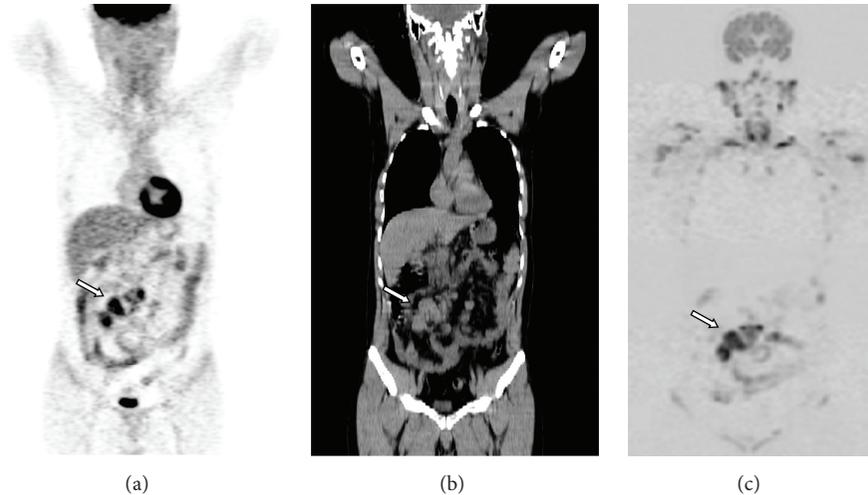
A 38-year-old man with intestinal DLBCL (diffuse large B-cell lymphoma): (a) MIP image of ^{18}F -FDG-PET, (b) coronal whole-body CT, and (c) MIP image of DWI. All techniques detected the primary intestinal lesion (arrow).
